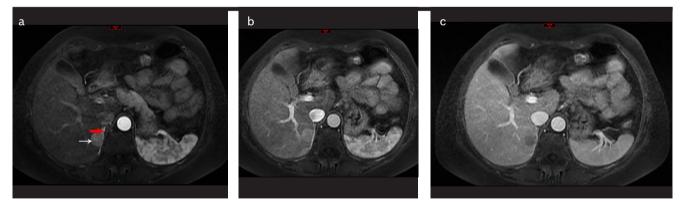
a-c. (a) Arterial phase magnetic resonance imaging shows enhancement of the mass (white arrow) and right adrenal gland (red arrow). (b) and (c): Contrast clearance can be seen in the portal vein phase and delayed phase. A normal right-side adrenal gland was visualized.
